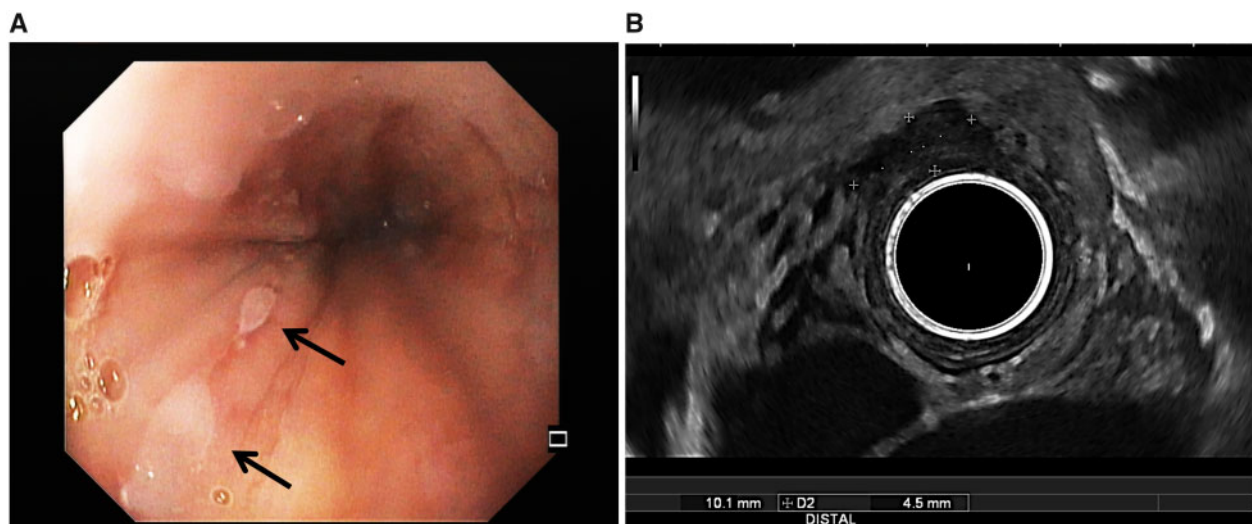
Manifestation of cold urticaria after cryoablation. Post-interventional oesophagogastroduodenoscopy revealed longitudinal oedemas (black arrows) with fissurated configuration in the middle oesophagus at 37–35 cm from the incisors (A). Additional endoscopic ultrasound demonstrated that each oesophageal oedema included all layers of the oesophageal wall and was accompanied by small mediastinal oedema, which was strictly restricted to peri-oesophageal tissue (B).
